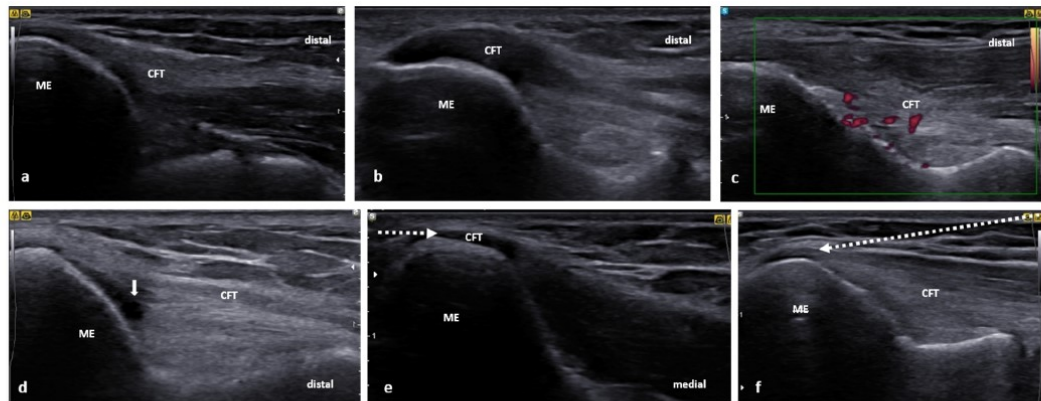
Ultrasound images of the CFT: (a) normal image of the CFT, (b) a severe thickening and hypoechoogenicity of the CFT, (c) US image demonstrating degenerative changes and hypervascularity in the CFT, (d) small ganglion (white arrow) in the CFT, (e) US-guided peritendinous CET injection showing the needle (white, dotted arrow) being inserted from medial to lateral in a short axis of the CFT, (f) the needle (white, dotted arrow) can also be inserted from distal to proximal along the long axis of the CFT.
